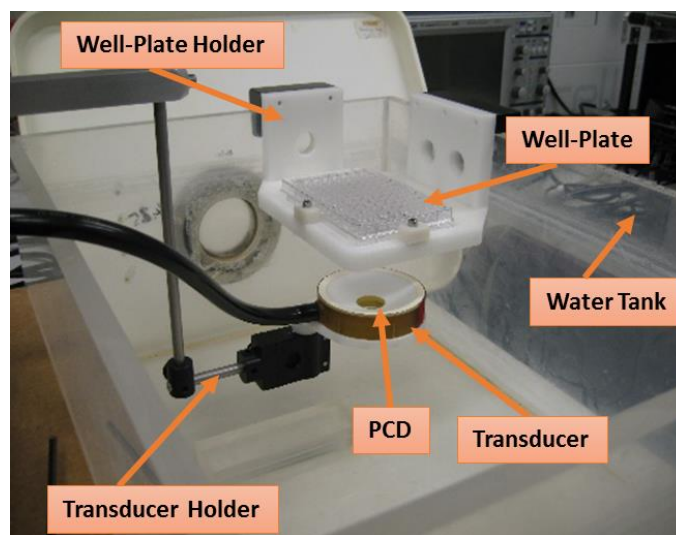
Example for setup to exposures *in vitro* (the tank is filled with degassed water prior to any exposure). The well-plate holder is holding a standard 96 well plate, which could not be used for US exposures because the thick perspex was not acoustically transparent and the plate could not be totally submerged. This means that there would be almost complete reflection of the ultrasound beam at the liquid air interface in each well and so, ultrasound exposure levels could not be accurately measured.
